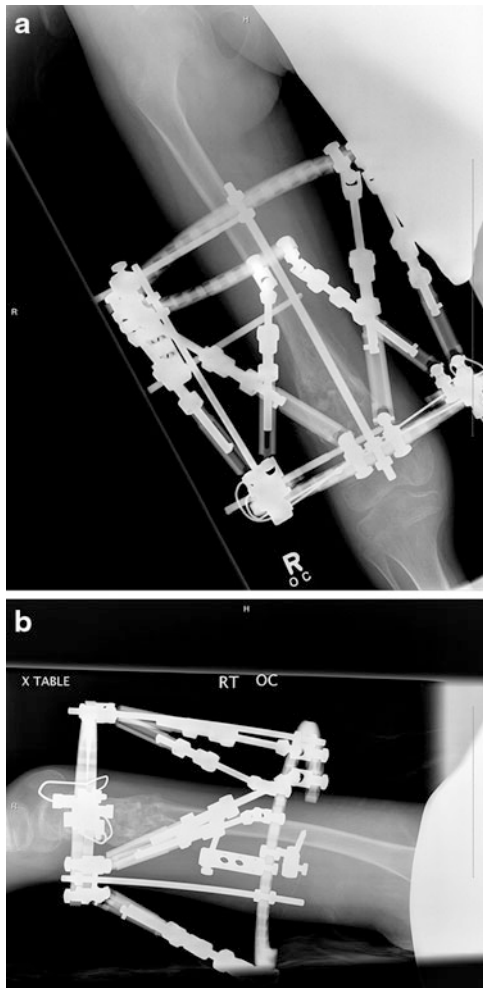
Antero-posterior (a) and lateral (b) radiographs reveal periosteal new bone formation at the fracture site with maintenance of alignment. Note that threaded rods were added to the frame to increase its stability and prevent loss of reduction from occurring
